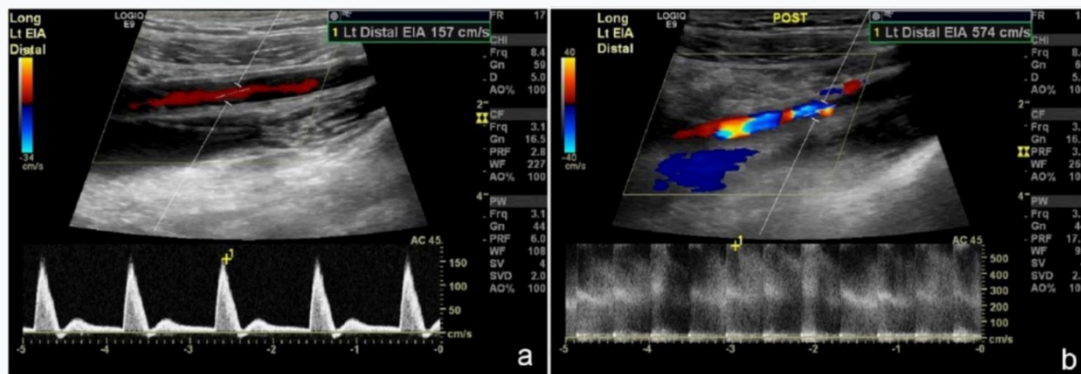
(a) Pre- and (b) postexercise DUS images of the external iliac artery in an elite female runner, with colour-Doppler visualisations (top) and peak systolic velocities (PSV) (bottom). Note significant postexercise increased flow velocity and mosaic Doppler pattern indicative of turbulence (Garlanger et al. 2017).
